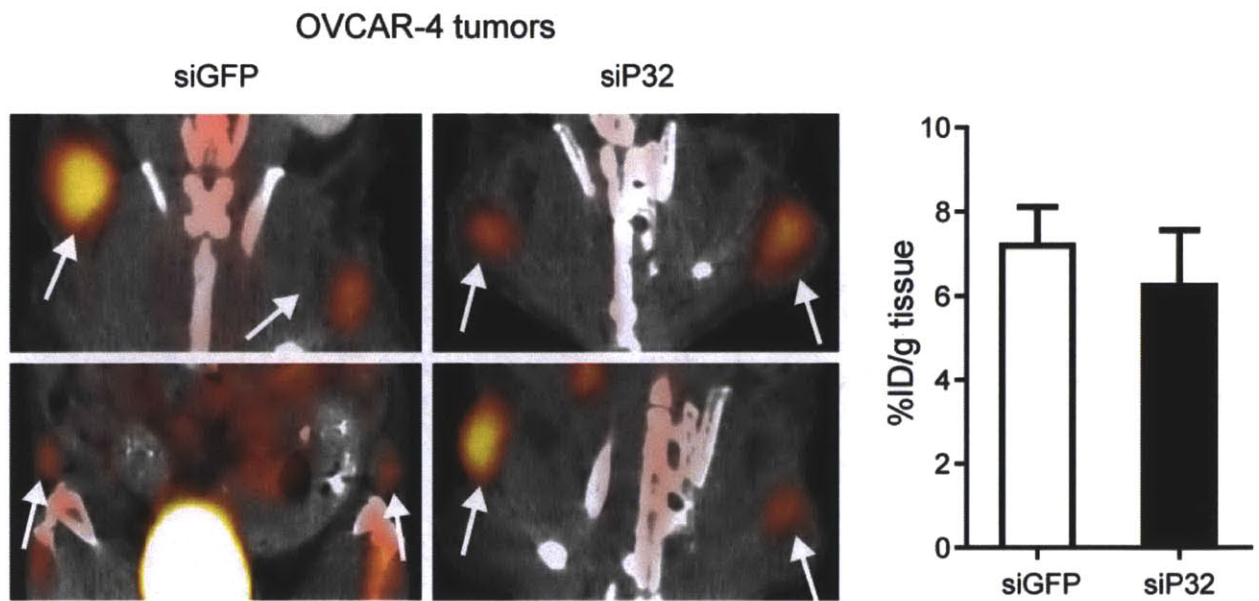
^{18}F -FDG-PET/CT imaging of OVCAR-4 tumor xenografts. Quantification of FDG tumor uptake is shown on the right.
